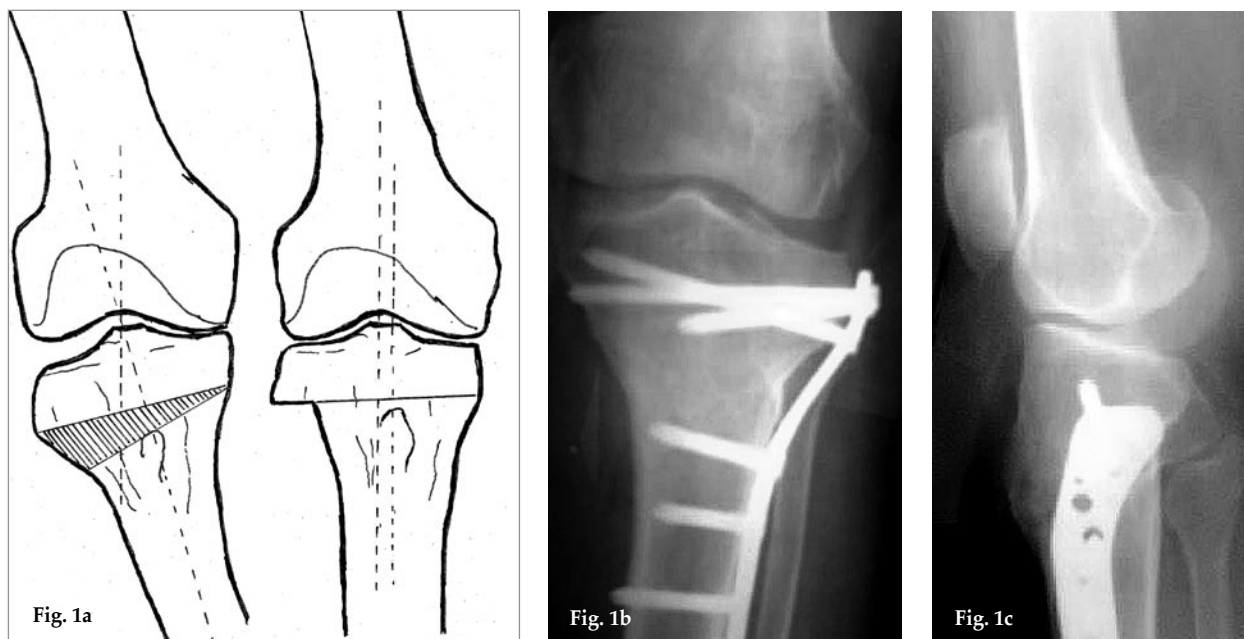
Lateral closing-wedge high tibial osteotomy. (b) Anteroposterior radiograph of a 56-year-old female patient in the 5<sup>th</sup> post-operative year. (c) Lateral radiograph of the same patient.
